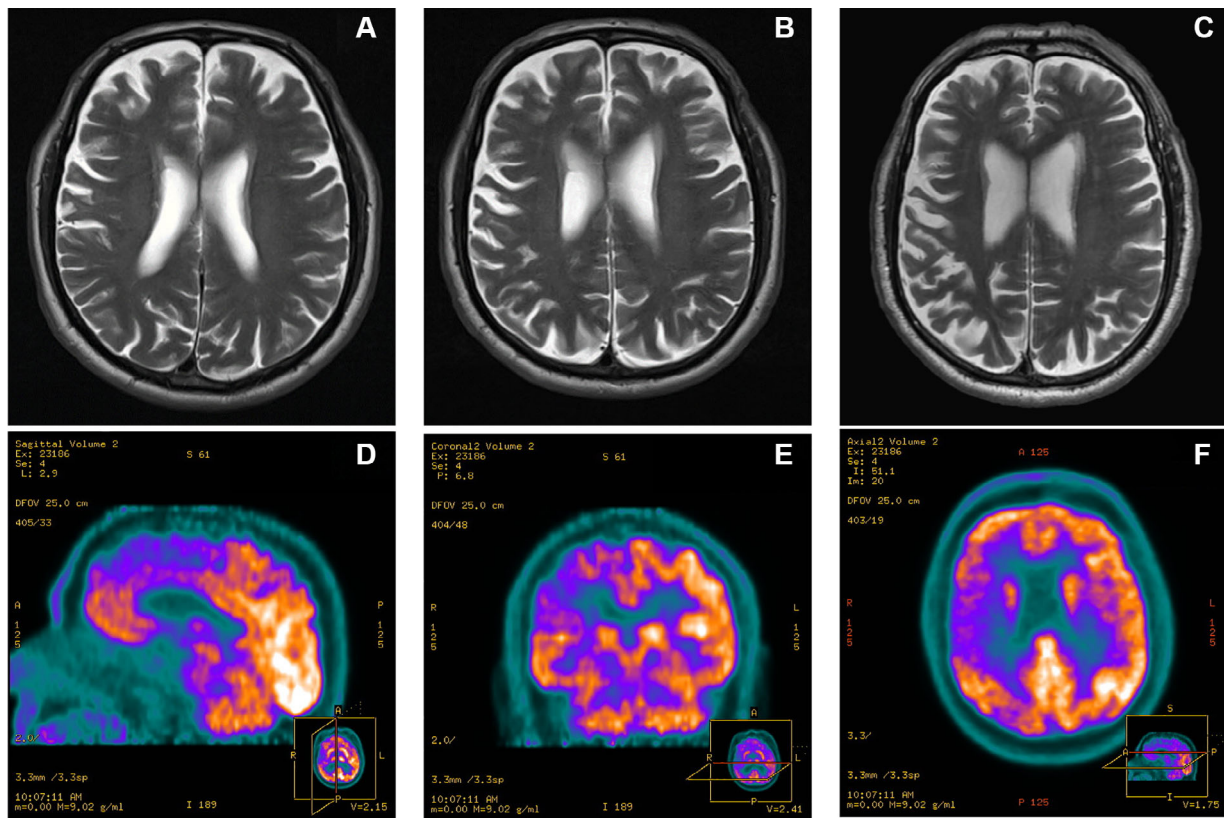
Representative T₂-weighted magnetic resonance imaging brain axial cuts at initial outpatient presentation (A), 18-month follow-up (B), and 36-month follow-up (C) show subtle progressive asymmetric brain atrophy, predominantly affecting the right frontal and parietal lobes, and positron emission tomography-computed tomography of the brain after the 36-month follow-up with representative sagittal (D), coronal (E), and axial (F) views shows asymmetrical cortical metabolism with reduced uptake in the right frontal and parietal cortices and in the basal ganglia in keeping with corticobasal syndrome.
